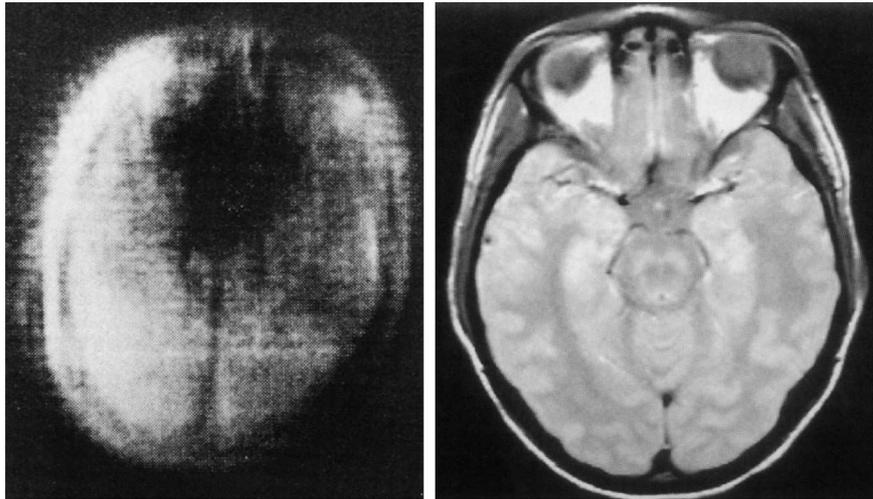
left*: The first published NMR reconstructed image of a head [from HOLLAND *et al.*, 1980]. *right*: MR image of a head, about 1993. Although approximately the same weighting is used as in the left image, system and sequence improvements have resulted in a better image being produced in less time. [from ORRISON *et al.*, 1995]
